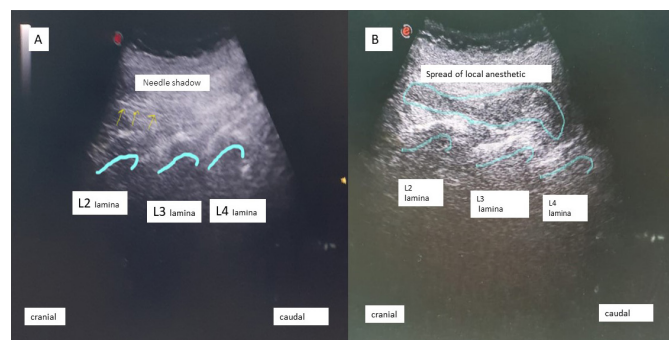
A) Ultrasonographic image of vertebral laminae and needle entry, B) Ultrasonographic image of local anesthetic spread
